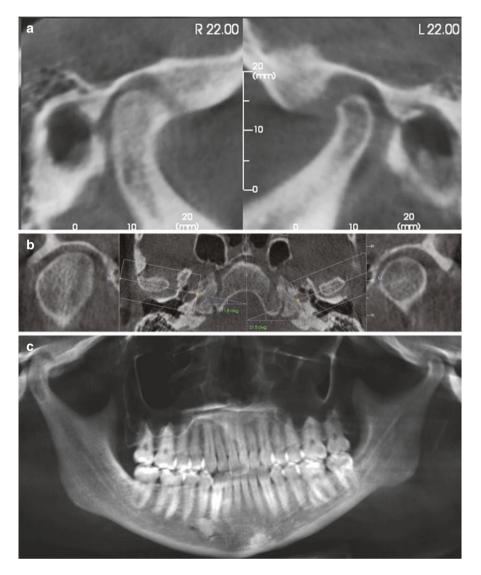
CBCT reformations in a patient with condylar hypoplasia shows reduction of condylar size on the left (a and b) with preservation of the position of the contours of the condyle previously discussed in Fig. 9.3, indicating that this is a developmental change and not reduction due to destruction. The result of the small condyle on the left is a small left side of the mandible (c-e). The differential diagnosis includes condylar hyperplasia on the right, but the morphology of the left side of the mandible indicate growth changes consistent with condylar hypoplasia
